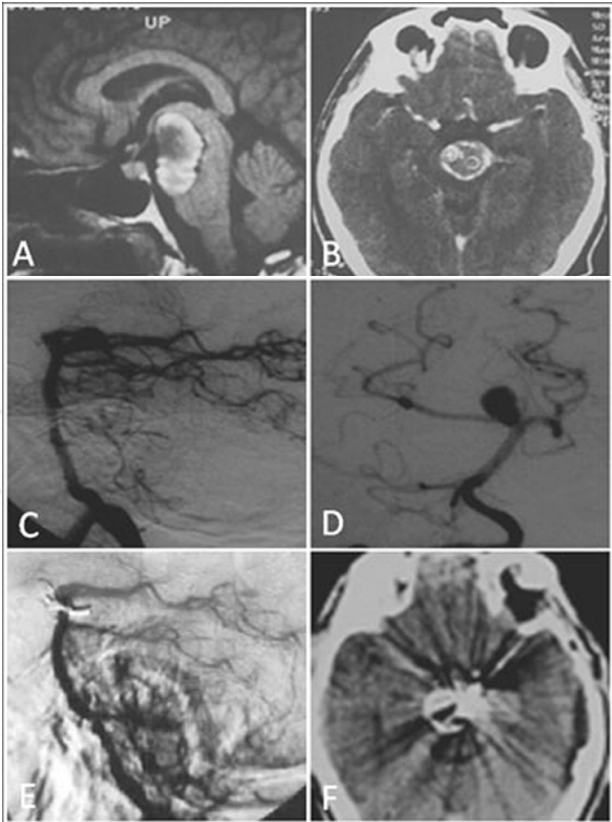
Preoperative MRI (A), preoperative CT scan (B), preoperative angiography (C,D), postoperative angiography (E) and postoperative CT scan (F) of a very large massively
